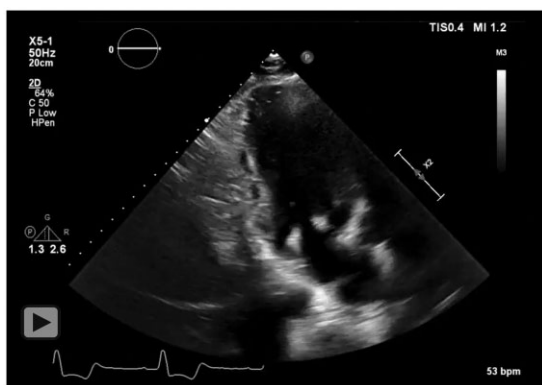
Preoperative transthoracic echocardiogram. (A) External institution left ventricular dimension measurements. (B) Retrospective analysis and re-measurement of left ventricular measurements, with increased interventricular septum size. (C) American Society of Echocardiography 2015 guidelines example for left ventricular dimension measurement.² (D) Interventricular hypertrophy evident on apical four-chamber view.
